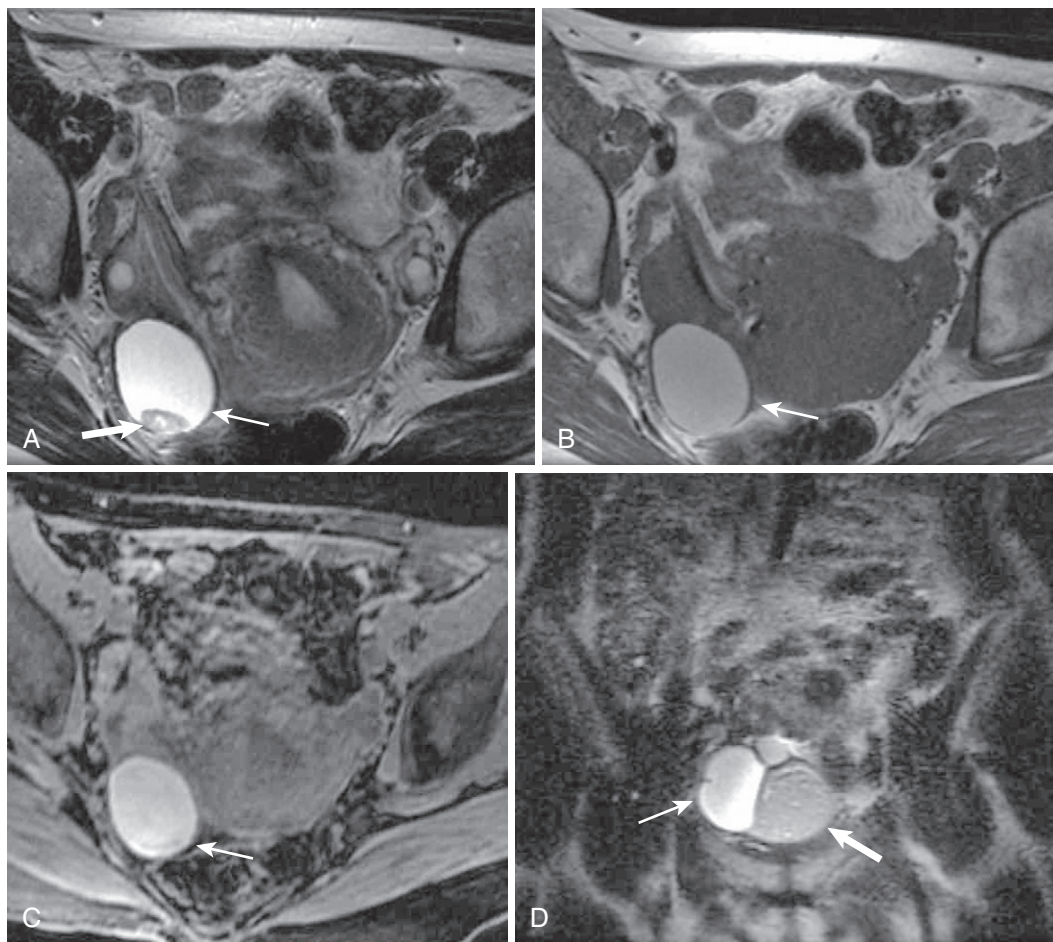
T1 hyperintense ovarian cysts—hemorrhagic cyst and dermoid cyst. The hemorrhagic cyst (*thin arrow* in A-C) exhibits hyperintense signal on all pulse sequences—T2-weighted (A), T1-weighted (B), and T1-weighted fat-suppressed (C) images. Dependent clot (*thick arrow* in A) and/or wall thickening occasionally complicate the appearance of hemorrhagic cysts. D-H, A biloculated dermoid cyst in a different patient contains water (*thin arrow*) and sebaceous or fatty (*thick arrow*) components. Although the sebaceous locule maintains signal on T2-weighted (D), T1-weighted out-of-phase (E), and in-phase (F) images, in contradistinction to the hemorrhagic cyst, signal is nullified with fat suppression (G). H, After gadolinium administration, no enhancement is observed in either lesion.
